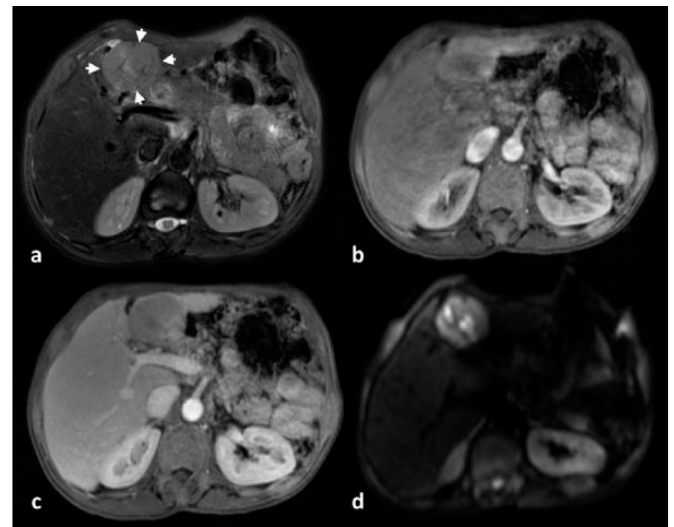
MRI images of the patient. (a) Mass lesion is seen on T2 weighted fat suppressed image (arrowheads). (b) Contrast enhancement is seen at late arterial phase image. (c) Wash-out of contrast in portal phase. (d) Intra-mass signal increase consistent with diffusion restriction on diffusion-weighted image
